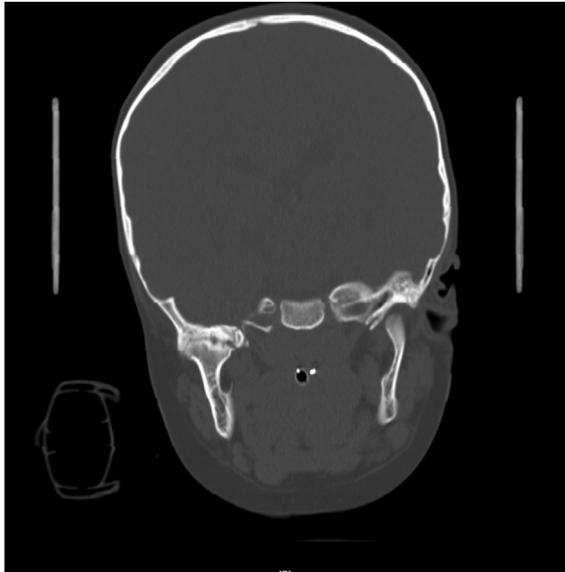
Coronal computed tomogram of the head showing ankylosis of the right temporomandibular joint and glenoid fossa.
